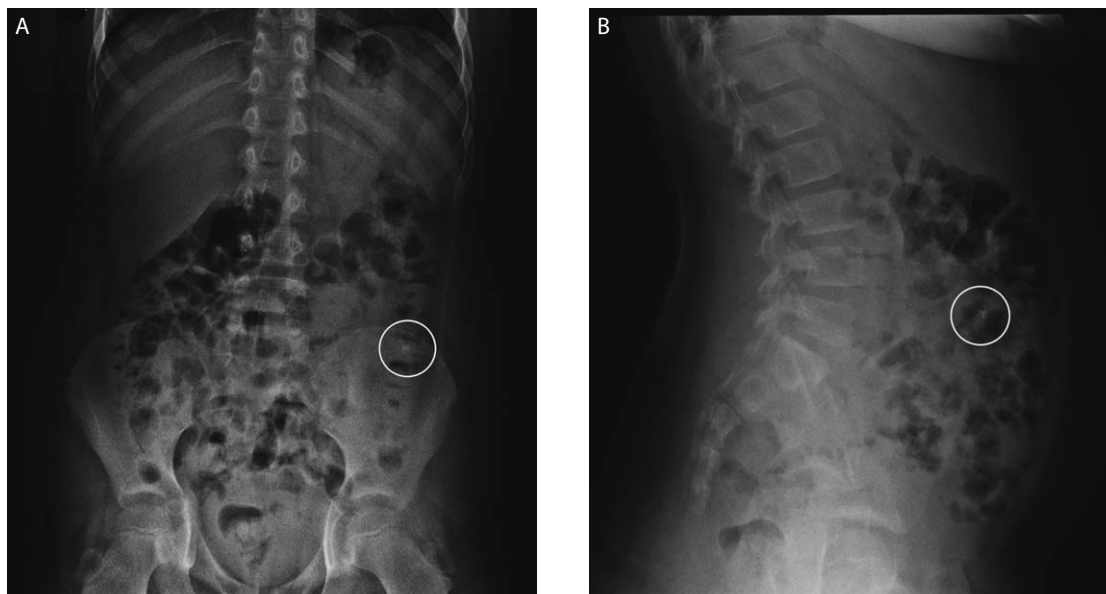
X-ray of the abdomen. Posterior - anterior (A) and lateral abdominal (B) view showing a triangular shadow of the tooth in the projection of the stomach (white circle).
